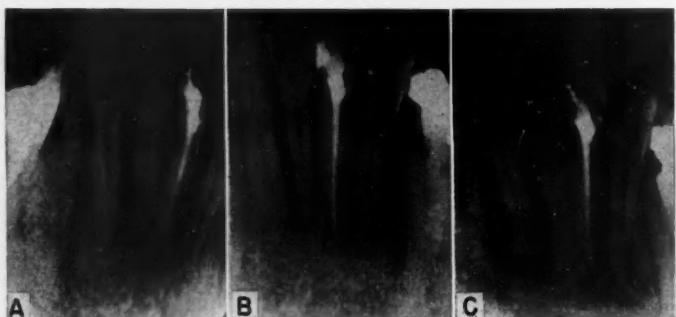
Lower incisor showing periapical rarefied area, the result of unsuccessful root canal filling 3 years previously. A, Before re-treatment; B, immediately after re-treatment; C, 14 months after re-treatment.
